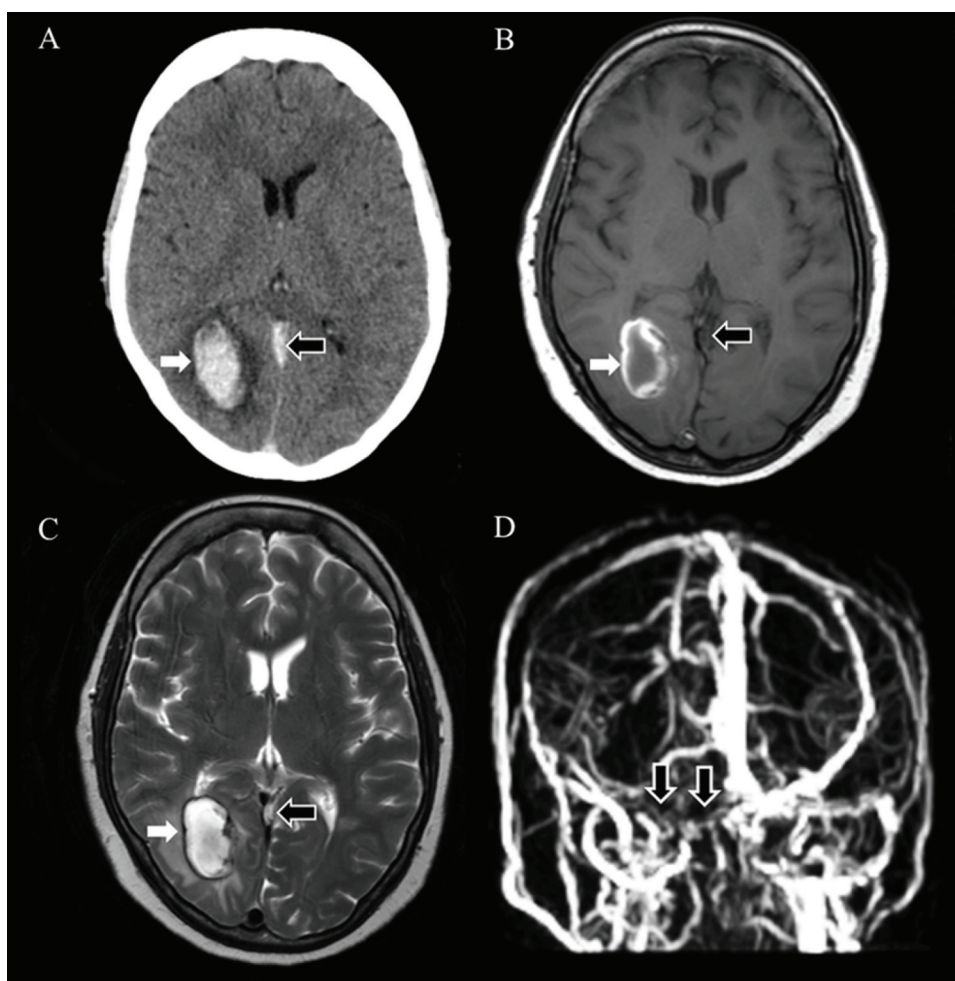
Axial unenhanced CT image (A) at the initial presentation showed an acute thrombus in the straight sinus (black arrow) and an acute hematoma in the right occipital lobe (white arrow). Axial T1-weighted MR image (B) and axial T2-weighted MR image (C) 1-month later showed a thrombus in the straight sinus (black arrow) and a subacute hematoma in the right occipital lobe (white arrow). Coronal reformatted image from contrast-enhanced MR venography (D) showed a filling defect in the right transverse sinus (black arrow) which is consistent with findings of thrombosis.
